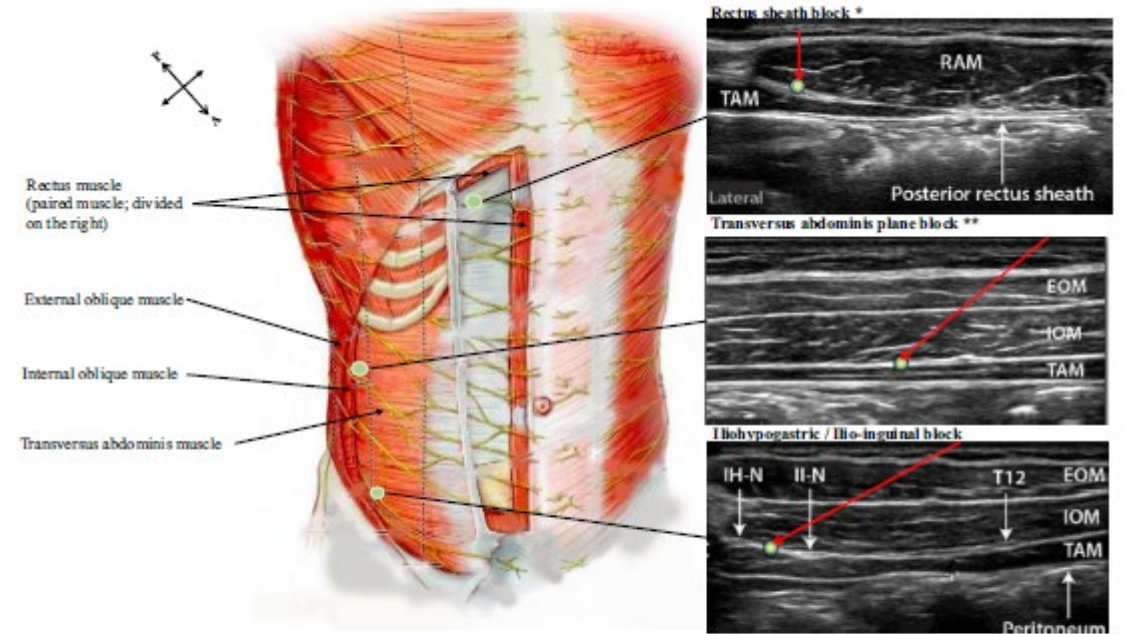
Anatomical and ultrasound representations of injection sites for rectus sheath, transversus abdominis plane and iliohypogastric and ilioinguinal nerve blocks. Green dot represents site for optimal placement of local anaesthetic; red arrows in ultrasound images indicate possible needle path to desired target; *paired muscle therefore bilateral injections required; denotes correct plane however posterior injection at the origin of the EOM and IOM muscles provides more complete coverage; RAM, rectus abdominis muscle; TAM, transversus abdominis muscle; EOM, external oblique muscle; IOM, internal oblique muscle; IH-N, iliohypogastric nerve; II-N, ilioinguinal nerve; reproduced with permission from *Regional Anaesthesia and Pain Medicine Journal*. P, posterior; A, anterior.
